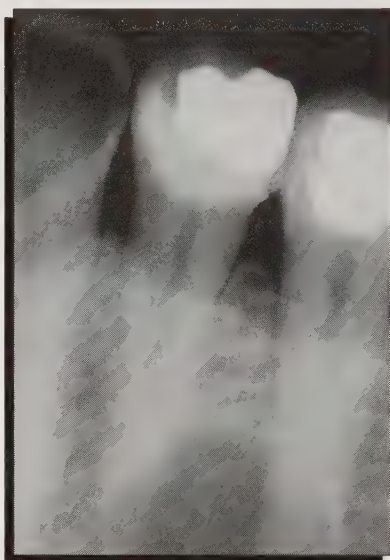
Periapical radiograph of the same LPC 25 months later. Note the increase in size and the multilocular pattern at its inferior aspect. Also, note that the teeth have not been resorbed or displaced.
